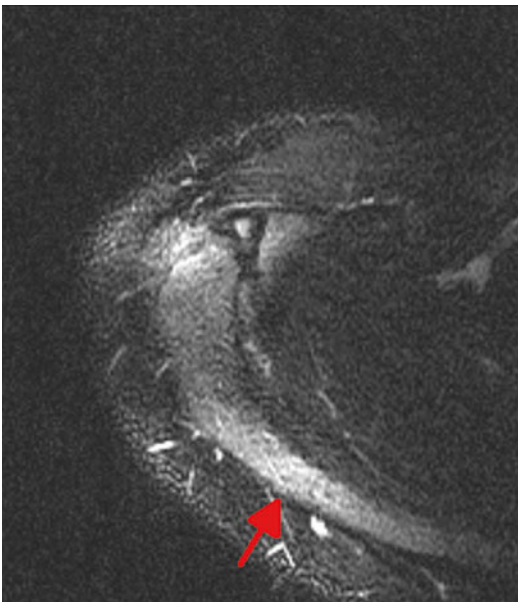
T2 axial MRI demonstrating Grade 2 stress fracture of the medial scapular spine in the dominant right shoulder of a high school quarterback. An unstable os acromiale is also evident
